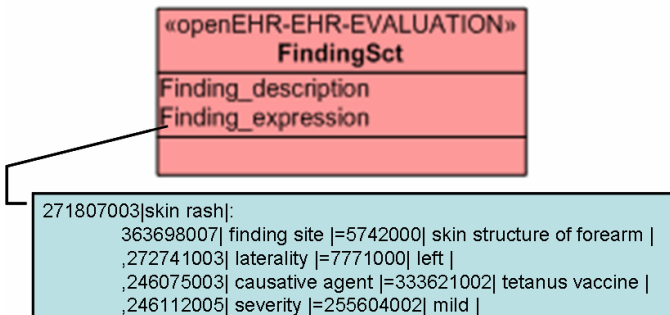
Using a SNOMED CT expression to represent the finding directly in an archetype
